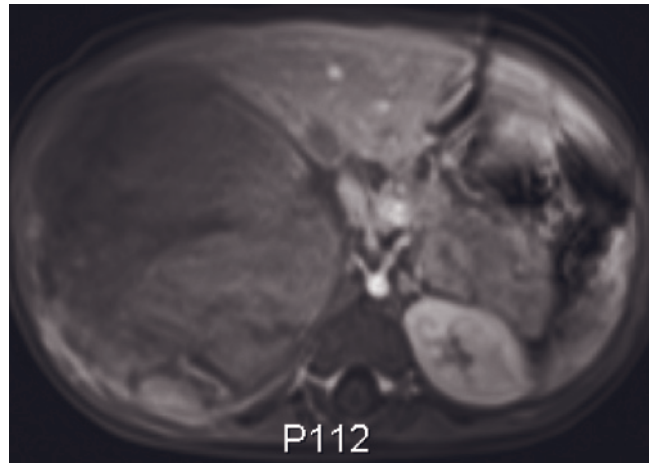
Motion resistant protocol in an 18-month-old boy at 3 T. Coronal T2-weighted single-shot echo-train spin-echo (a), coronal water-excitation MP-RAGE (b), axial T2-weighted single-shot echo-train spin-echo (c), axial water-excitation T1-weighted MP-RAGE (d), and immediate (e) and 60-s (f) postgadolinium water-excitation MP-RAGE. All images show a large hepatoblastoma in the right lobe of the liver. All sequences are obtained without the requirement for breath holding. There is improved signal-to-noise ratio (SNR) with the use of 3 T magnet.
